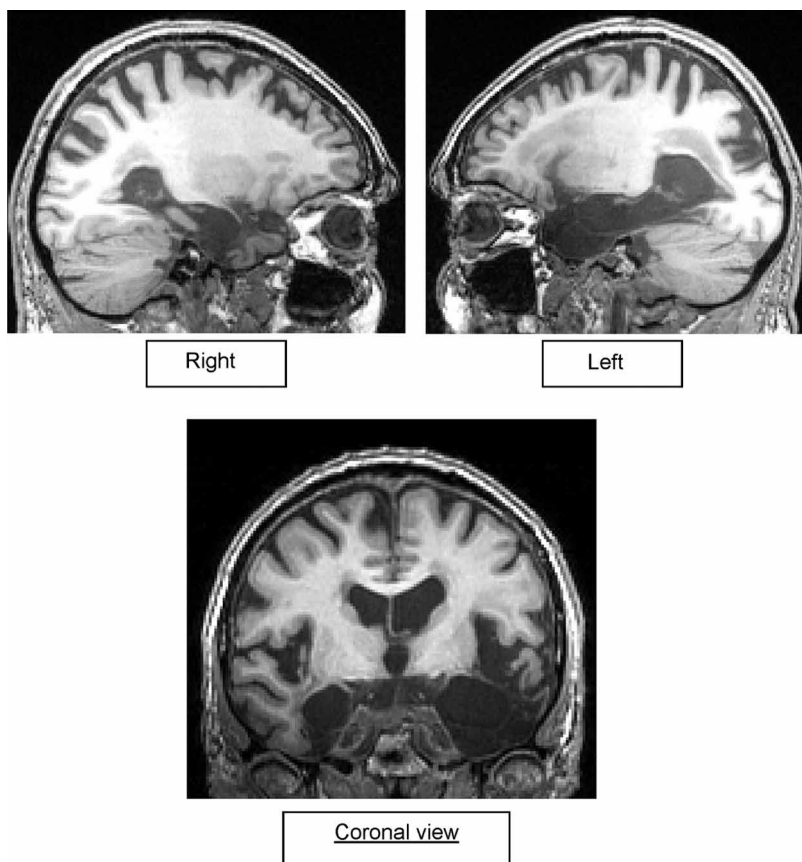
MRI 2006 showing that CW has extensive damage to the temporal cortices, greater on the left than on the right.
